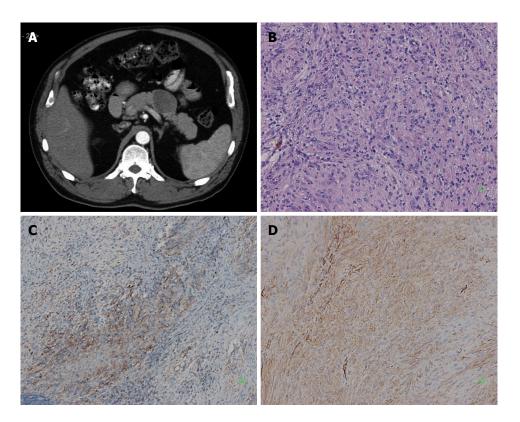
An abdominal mass was detected by ultrasound in a 61-year-old man with no clinical symptoms. A: Enhanced abdominal computed tomography scan showed a solid mass of the pancreatic body, and the tumor located at pancreas tail next to splenic artery; B: The tumor was composed of spindle cell (HE, × 200); C: Immunoreactivity of the tumor cells for CD117 was positive (+) (SP × 100); D: Immunoreactivity of the tumor cells for CD34 was positive (++) (SP × 200).
